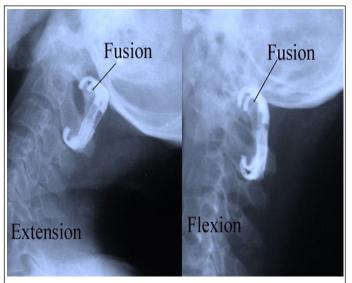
1 year follow up x-ray in extension and flexion showing fusion of C1-C2 posterior arch.
